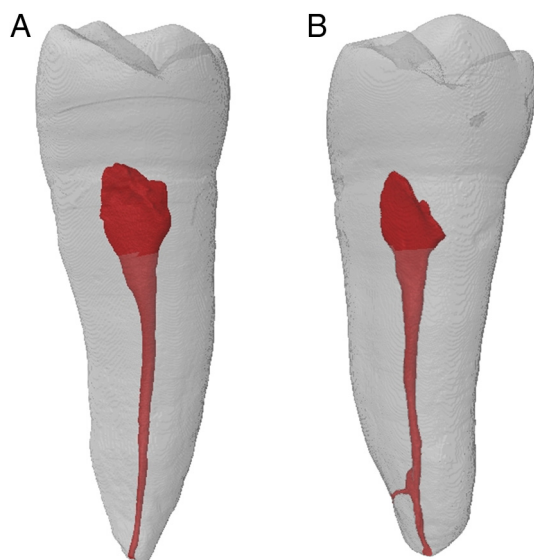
μ CT 3-dimensional reconstruction. (A) An example of a tooth with absence of an LC. (B) An example of a tooth with an LC.
